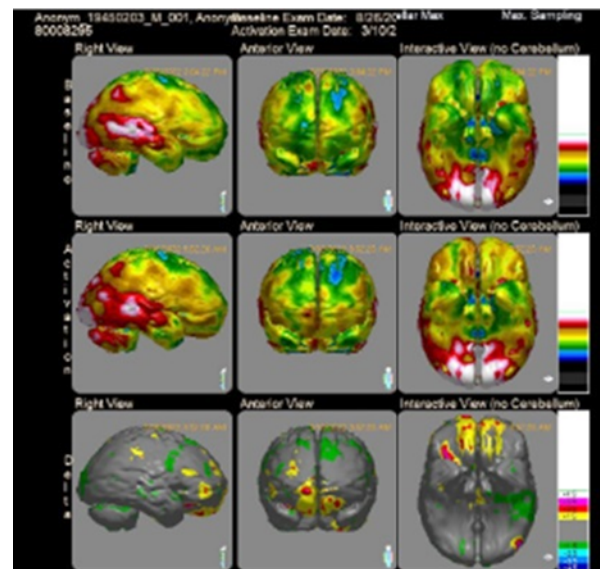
Case #1 SPECT images (upper row – before HBOT; Middle row- after HBOT; Lower row – Delta change).
